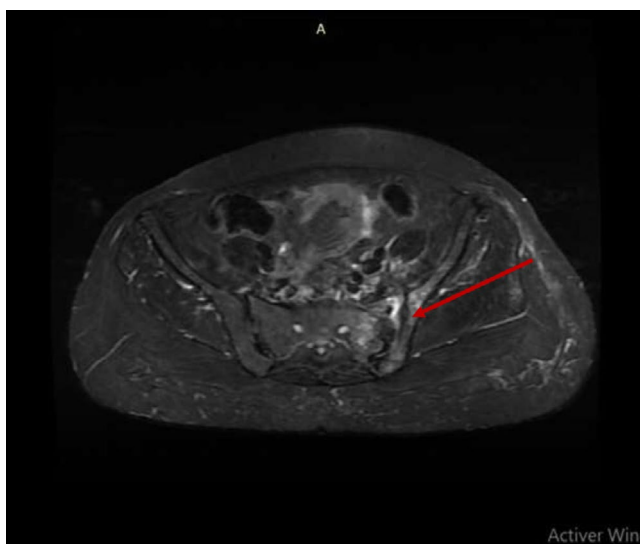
Magnetic resonance imaging (MRI) of the pelvis showing a left sacroiliitis and a collection in the left sacroiliac joint (arrow)
